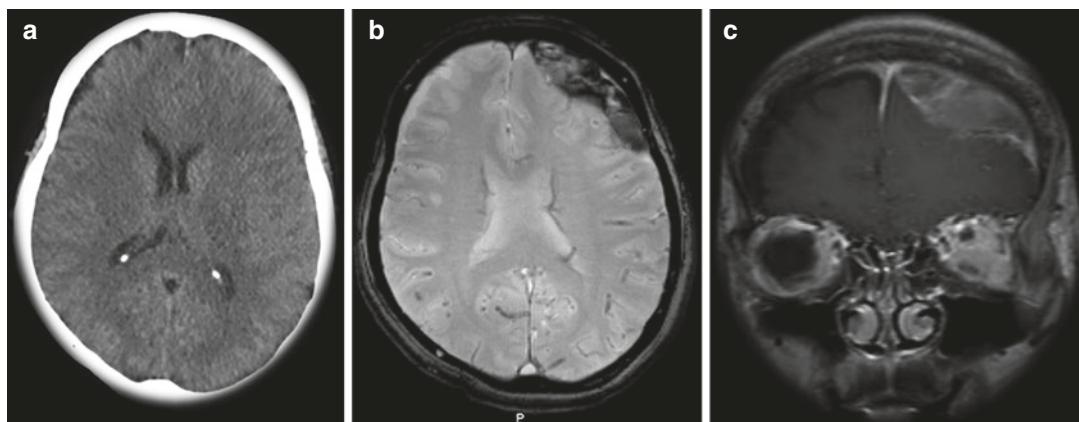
Representative axial head CT image without contrast (a), of a 50 year-old patient who presented with persistent headache 2 weeks after a head trauma. The scan was reported as normal. Axial GRE (b) and coronal
